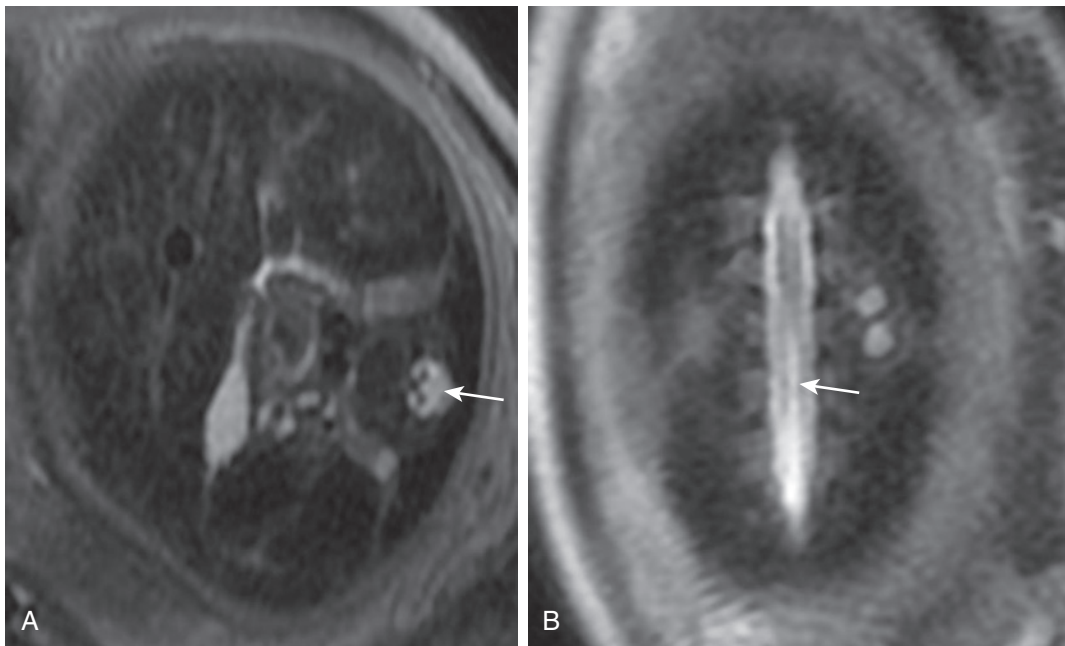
Diastematomyelia. Fetal magnetic resonance imaging (T2 weighted) showing axial (A) and coronal (B) views through the spine. Note the bifid shape of the spinal cord in both views (arrows).
